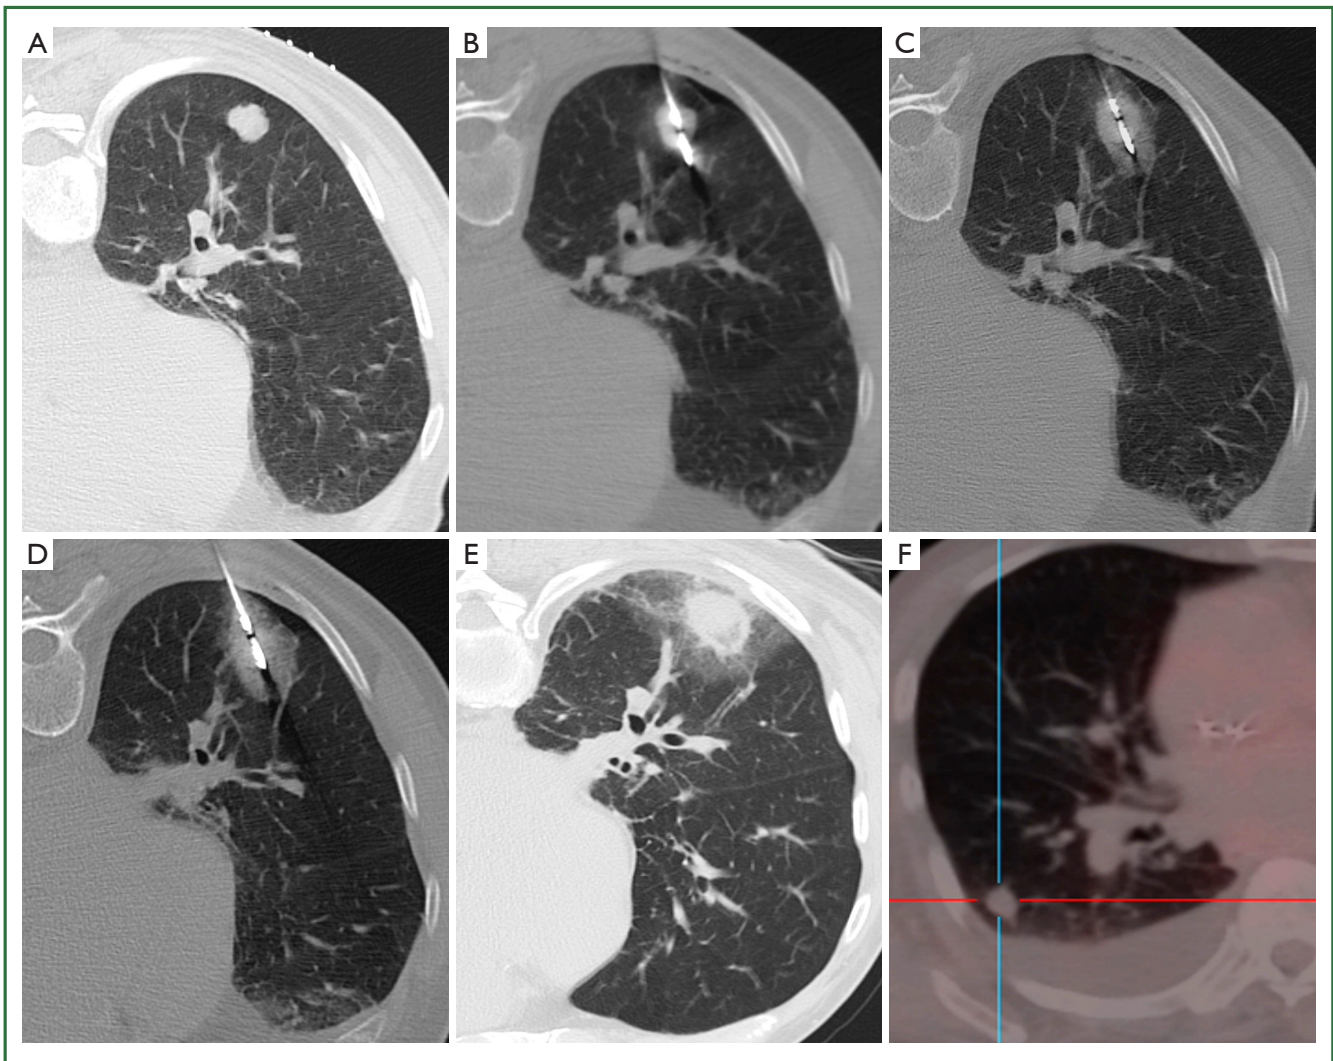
A 70-year-old man with cardiomyopathy and new solitary melanoma metastasis to the right lower lobe. A. Prone axial CT image shows a lobulated 1.6 cm tumour; B. The feed point of the microwave antenna is positioned within the centre of the tumour; C, D. At 5 minutes following the start of ablation (C), there is ground glass opacity forming mainly on the far edge of the tumour, and at 10 minutes (D), a 3-10 mm circumferential rim of ground glass opacity has formed around the tumour; E. At 3 hours following ablation, there is marked (>1 cm) circumferential ground glass opacity around the tumour; F. Axial FDG-PET/CT image 6 months following MWA shows complete lack of FDG uptake at the site of tumour, indicating eradication of tumour. New cardiac-related pleural effusion is present.
